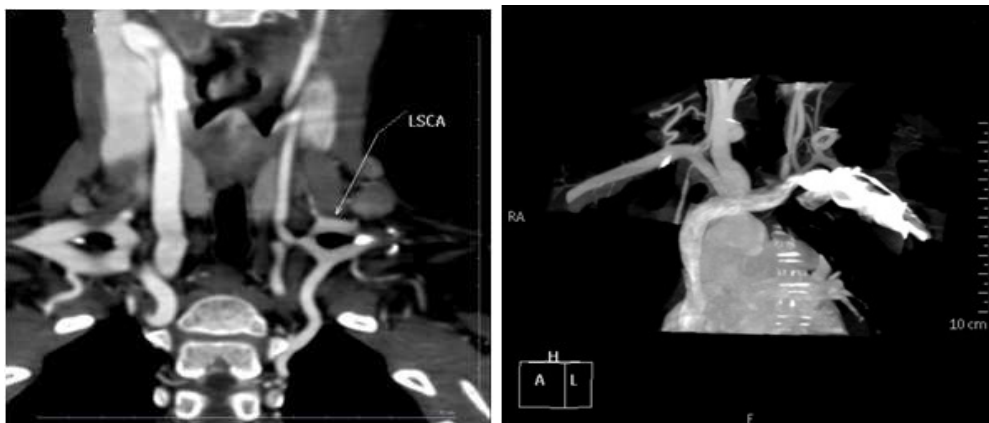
Patient's CT angiogram; (A, left image,) and (B, right image); (A) left carotid artery was significantly narrower than the right one; (B) the left subclavian artery aroused from this narrow carotid artery
